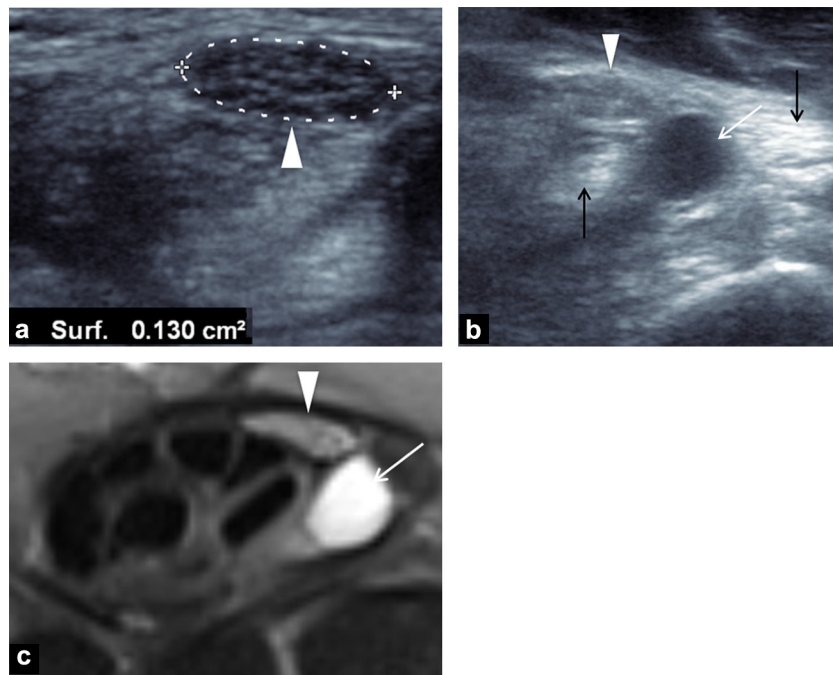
Left carpal tunnel, atypical considering gender and the young age in a 33-year-old man, revealing a deep palmar arthrosynovial cyst located at the distality of the carpal tunnel. a: ultrasound shows median nerve (arrowhead) with increased diameter; b: performing tilting movements with the probe allows bringing up tendons (black arrows), subject to anisotropy, hyperechoic. Thereby, it is easier to distinguish the anechoic cyst (white arrow) from them; c: fat-saturated proton density-weighted image in the transverse plane shows the compressive arthrosynovial cyst (white arrow). Increased signal intensity of the median nerve may indicate distress (arrowhead).
